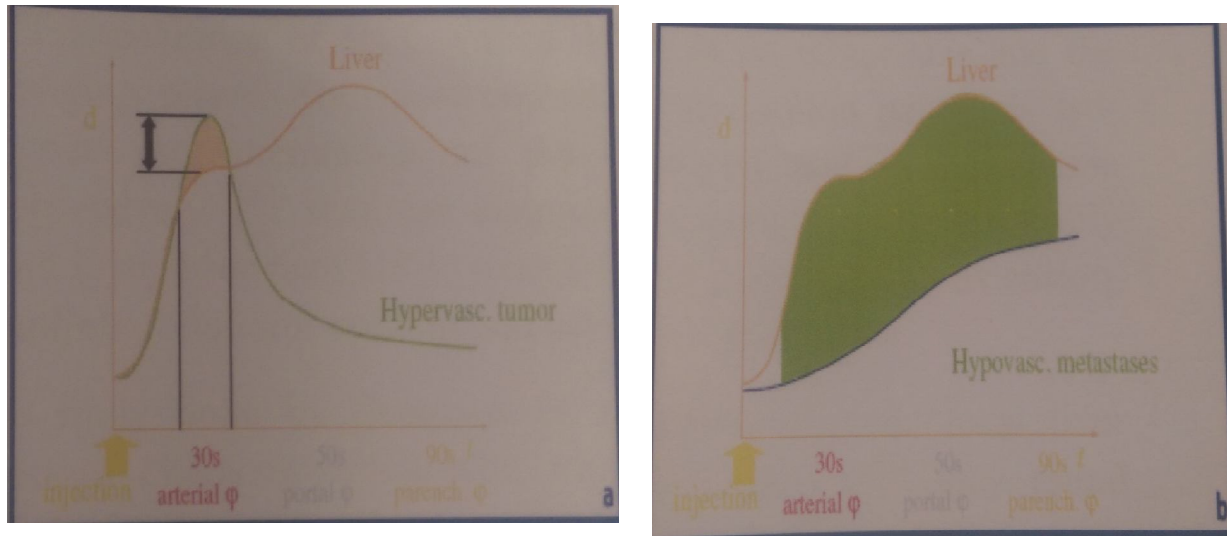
Showed enhancement profiles of normal liver and liver tumors during the three vascular phases of contrast- enhanced CT The vascular phases. are defined in relation to the moment of injection (time 0) and are the arterial phase (20-35s), portal venous phase (50-60 s),and late(parenchymal) phase (after several minutes).
